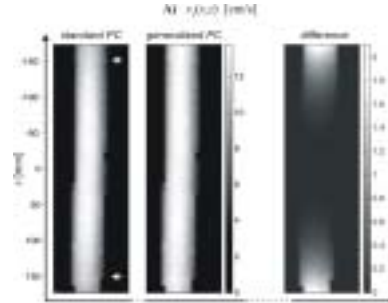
3D phase contrast MRI with three-directional velocity encoding: Two dimensional intensity plots reflecting velocity profiles in the coronal (x - z) plane for velocities encoded along z . The images show velocity profiles for standard (left, standard PC) and generalized phase contrast reconstruction (middle, generalized PC) as well as the difference between both methods (right).
